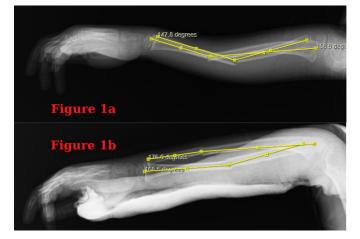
Pre-reduction (Figure 1a) and Post-reduction (Figure 1b) Lateral Radiographs of 7 years old boy with both radius and ulna diaphyseal forearm fractures were treated by Emergency Physician.
